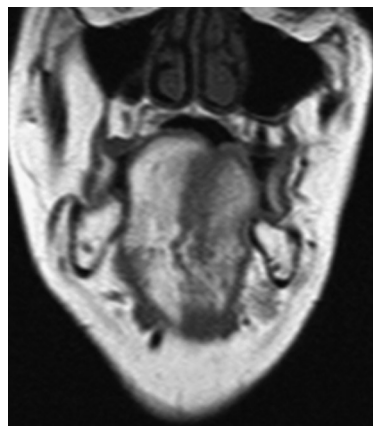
Magnetic resonance imaging spin echo T1 sequences in the coronal plane.
